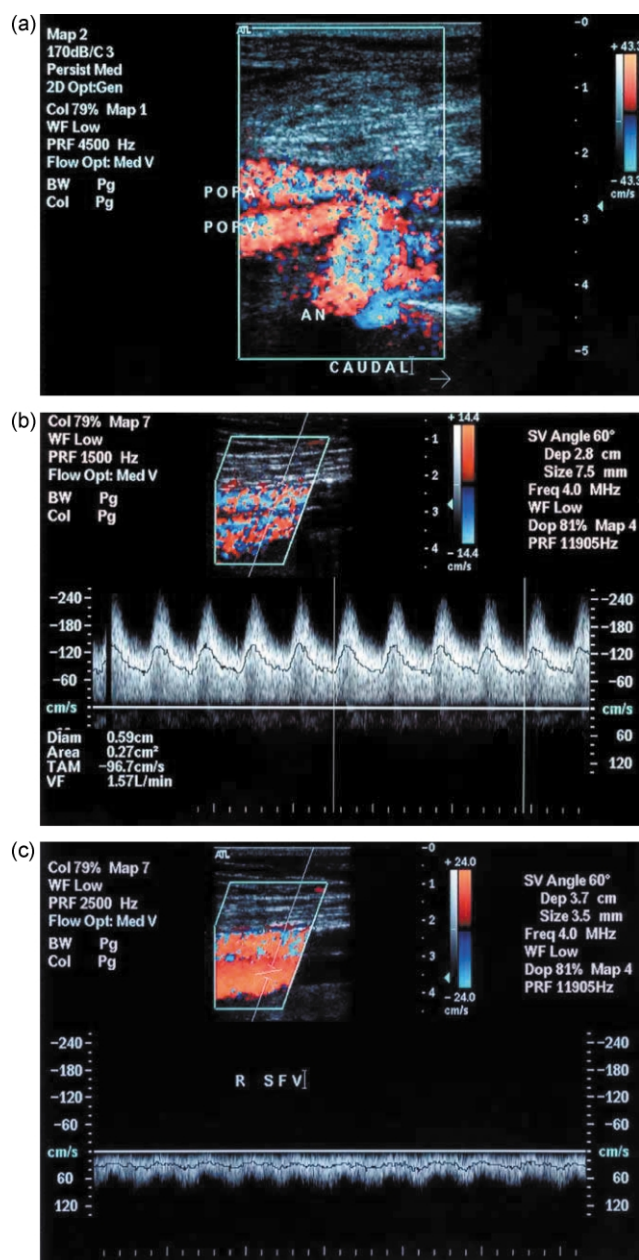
Ultrasound duplex scan. (a) The popliteal pseudoaneurysm and AVF. (b) Shows high velocity, pulsatile flow in the superficial femoral artery. (c) Shows high velocity, pulsatile flow in the superficial femoral vein.
